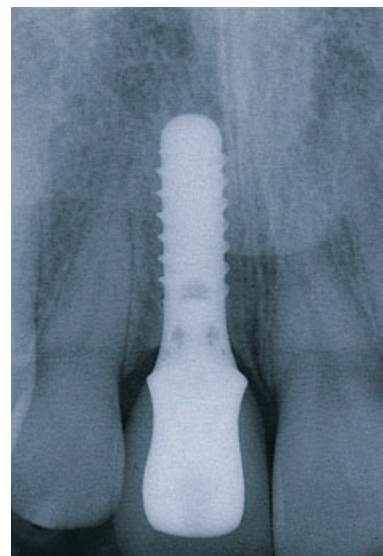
The 1-year post-operative radiograph confirms favorable conditions at the bone-to-implant interface. Note a high degree of radio-opacity of the all-ceramic substrate, permitting the evaluation of the fidelity of the marginal adaptation.
